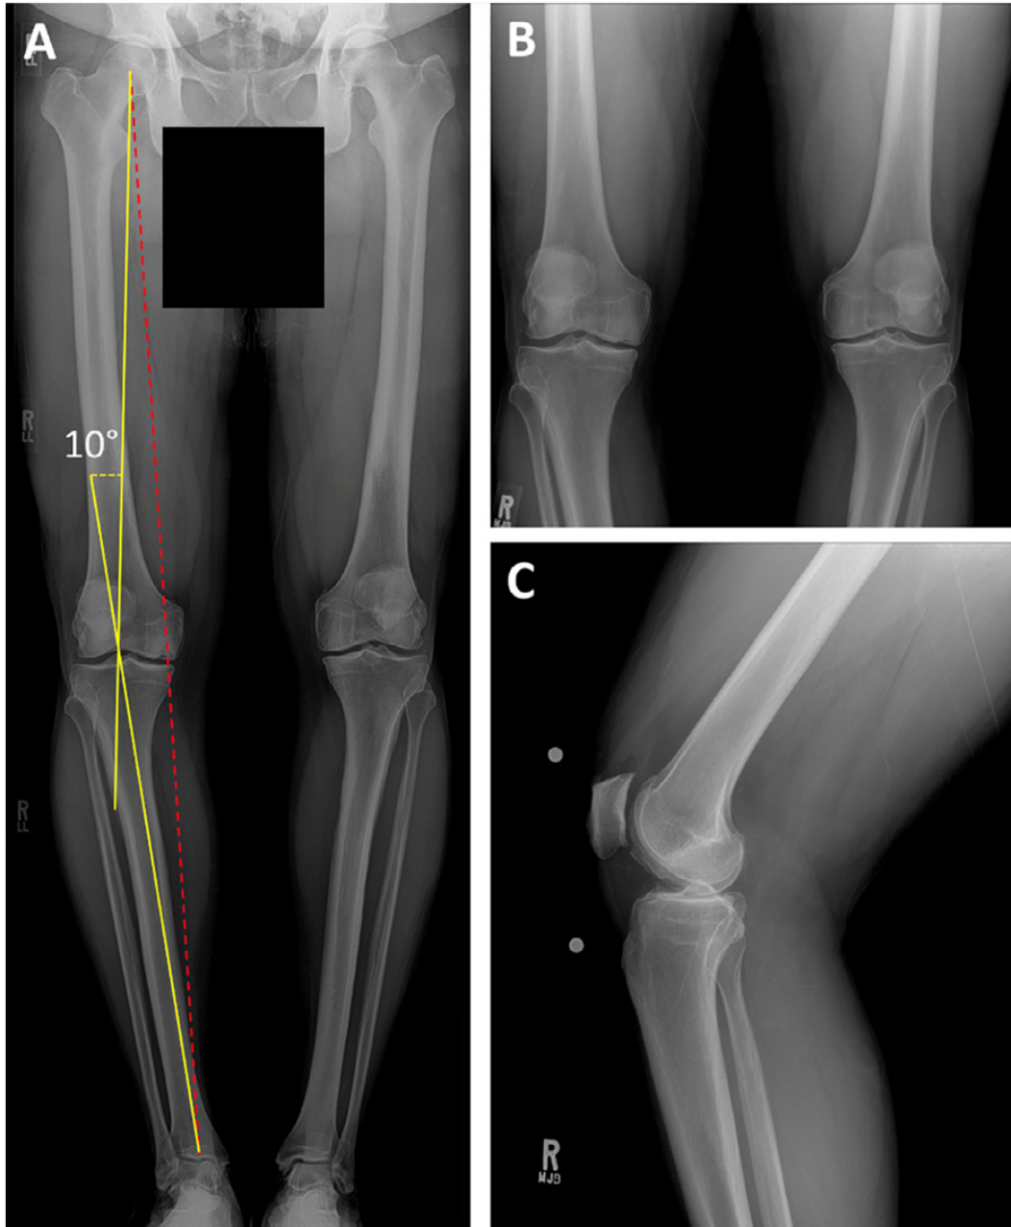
Preoperative radiographs (A) A representative standing weight-bearing radiograph showing a varus deformity that predisposes the patient to medial compartment osteochondral disease to assess sagittal alignment. (B) An example of a standing anteroposterior radiograph of both knees, perhaps demonstrating an osteochondral lesion of the right medial femoral condyle. Right knee lateral radiograph (C) (11)
